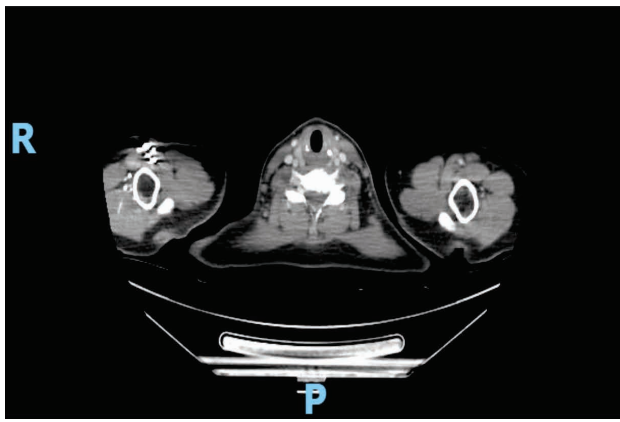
MRI showing vertebral metastases
